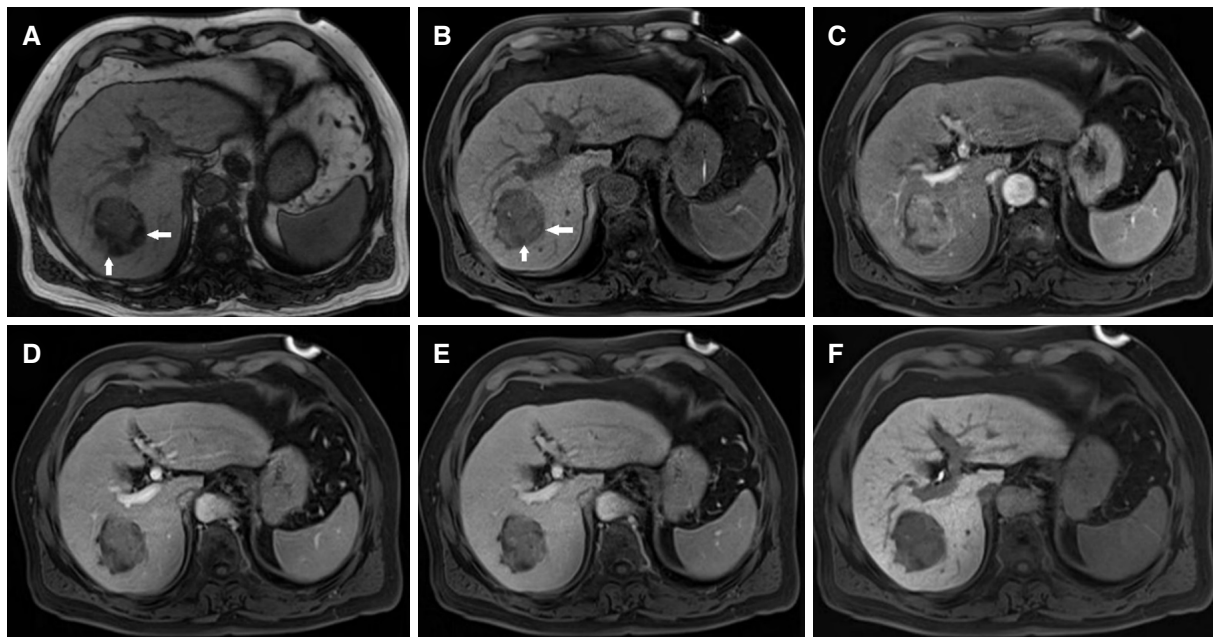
A 54-year-old female with hepatocellular carcinoma in segment VII of the liver. The 4.2-cm-sized mass shows focal fatty infiltration (white arrows) on opposed phase image (A) and unenhanced T1-weighted image (B), marked enhancement in arterial phase (C), wash-out appearance in portal venous phase (D) and delay phase (E), and hypo-intensity on 20 min hepatobiliary phase (F)
